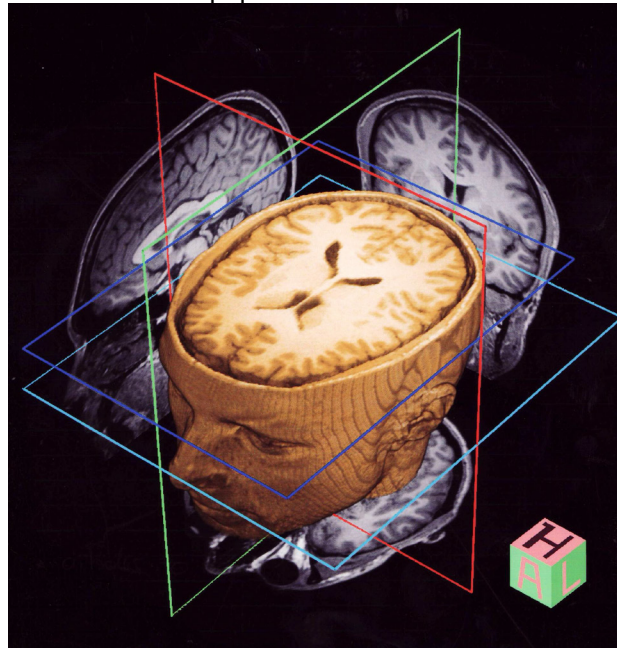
The selection directions of MRI slices
